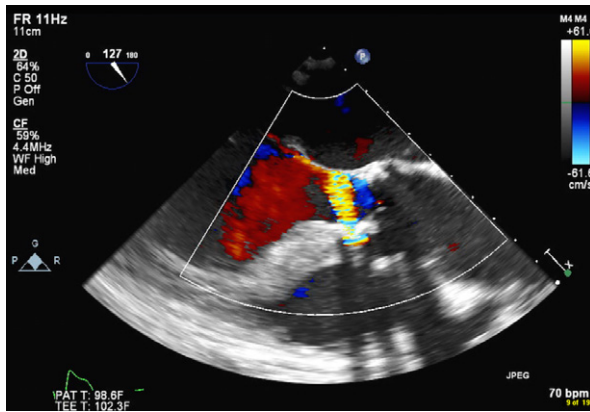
Two-dimensional transesophageal echocardiogram shows severe aortic regurgitation caused by a crescent-shaped paravalvular leak.
